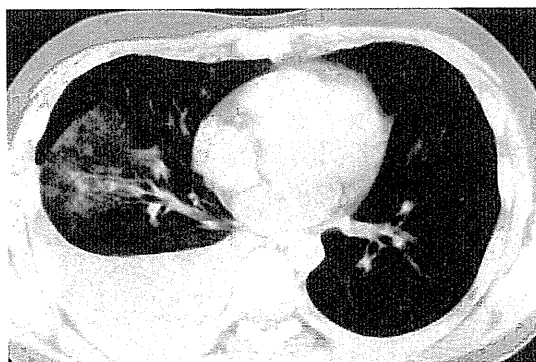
Thoracic CT. Thoracic CT and thoracentesis revealed hemopneumothorax.
